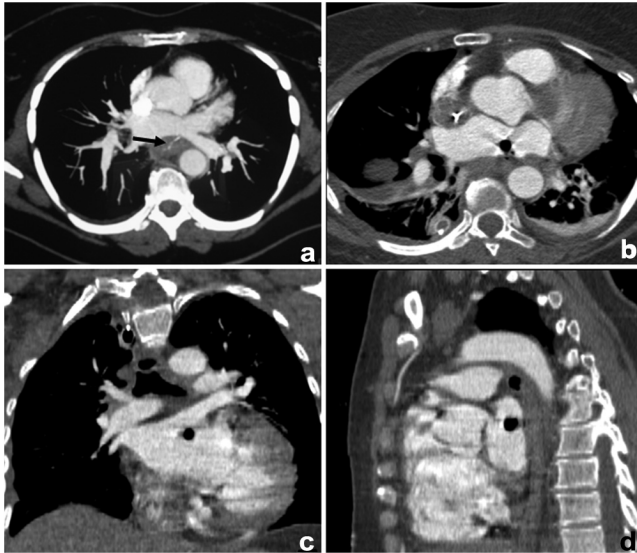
CT images. (a) A fishbone in the esophagus in contact with the left atrium (arrow). (b, c and d) A bubble in the left atrium demonstrated on different CT sections of the thorax. Mediastinal, pleural or pericardial air collections can be excluded and air embolism may be assumed.
